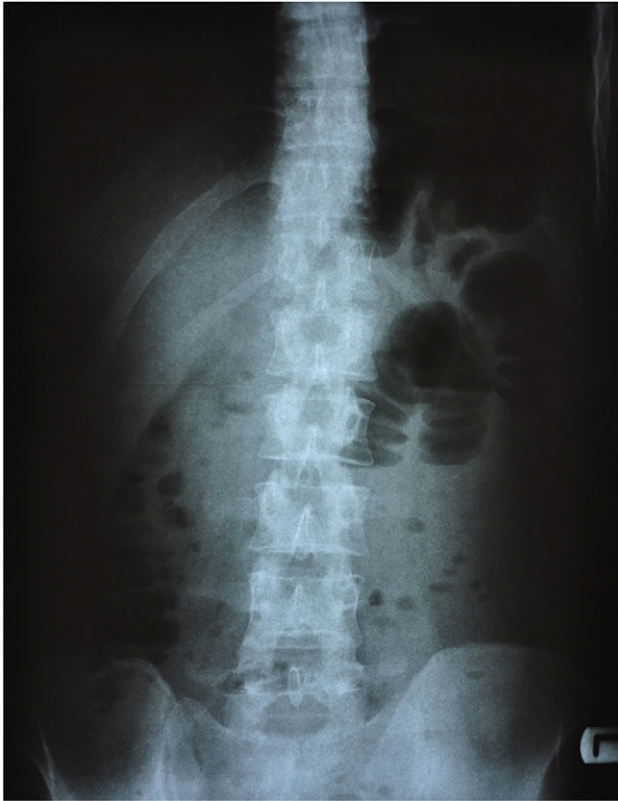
Plain abdominal X-ray: Demonstrated distended central bowel loops.
